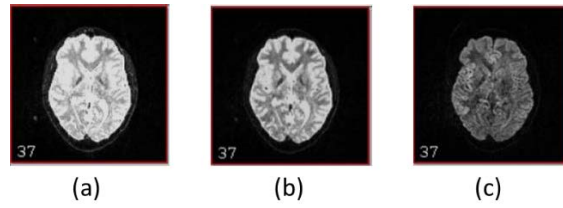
Different DWI images of the same subject with different b-values. (a) diffusion weighted image with $b=0$. (b) diffusion weighted image with $b=1000$. (c) diffusion weighted image with $b=2000$.
